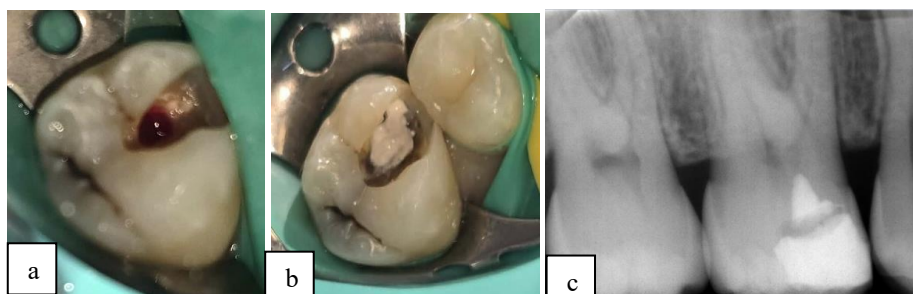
[a] Partial removal of the coronal pulp tissue adjacent to the carious lesion. [b] pulp capping with MTA. [c] post-operative radiograph
